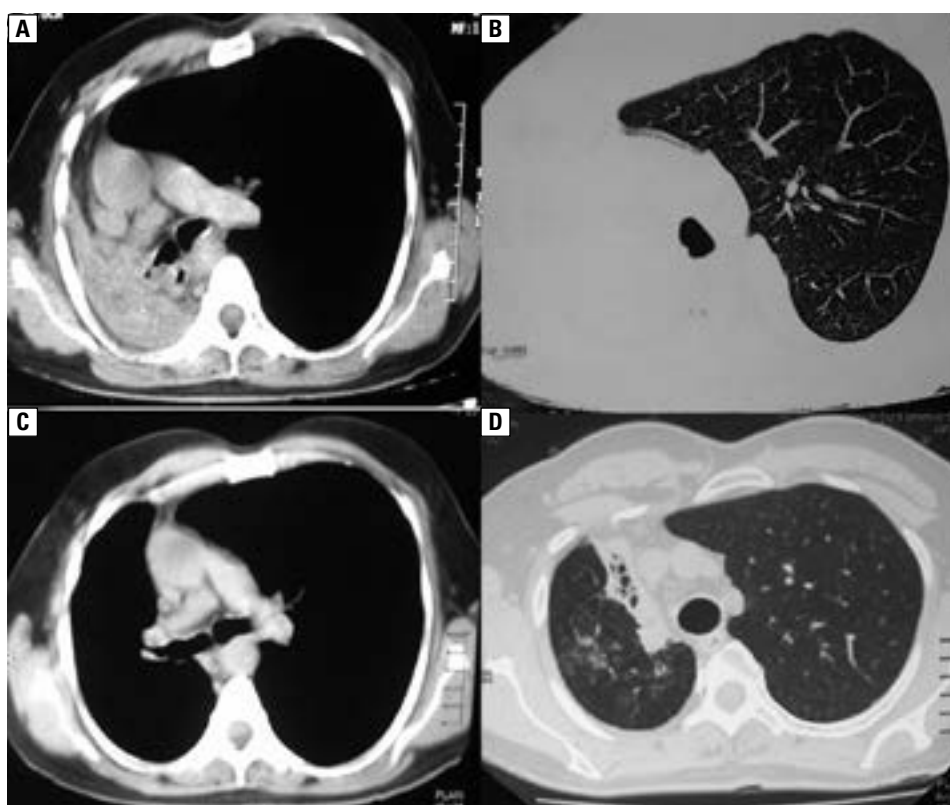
High resolution computed tomography of the lung of patient in case1 (A, B) Collapsed right lung at presentation with mediastinal shift to right (C, D) Re-expanded right lung after treatment
